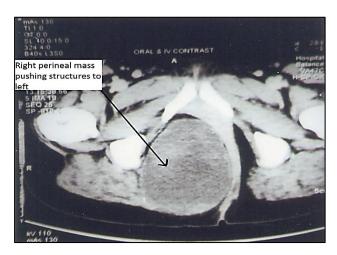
A section of CT scan shows mass in the right perineum pushing the perineal structures to the left.
